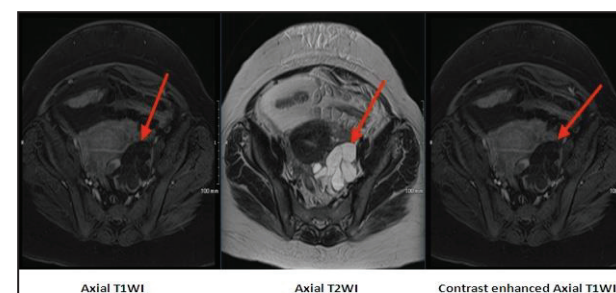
MRI pelvis images showing left sided hydrosalpinx (arrow)
